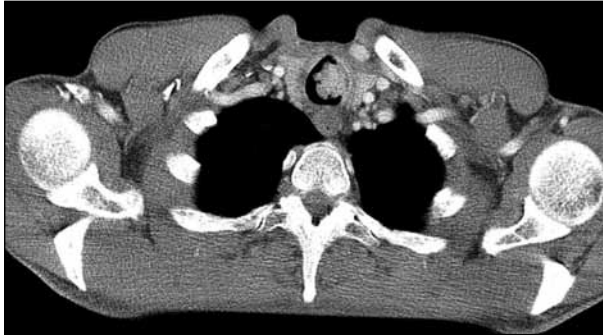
A computed tomographic scan of the chest shows the tumor, which occupies approximately 90% of the tracheal lumen
